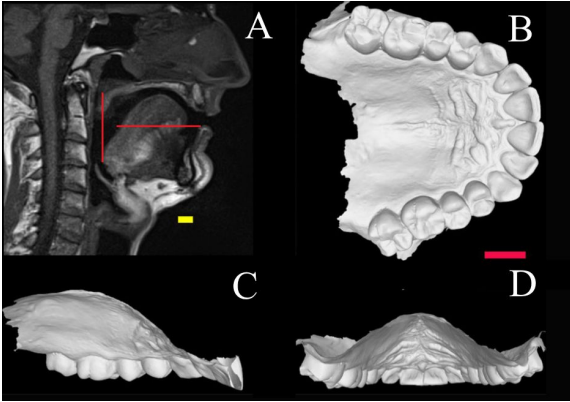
MRI of an Oral Cavity. Scale bar at 1cm. Image reproduced with modifications from [55].
